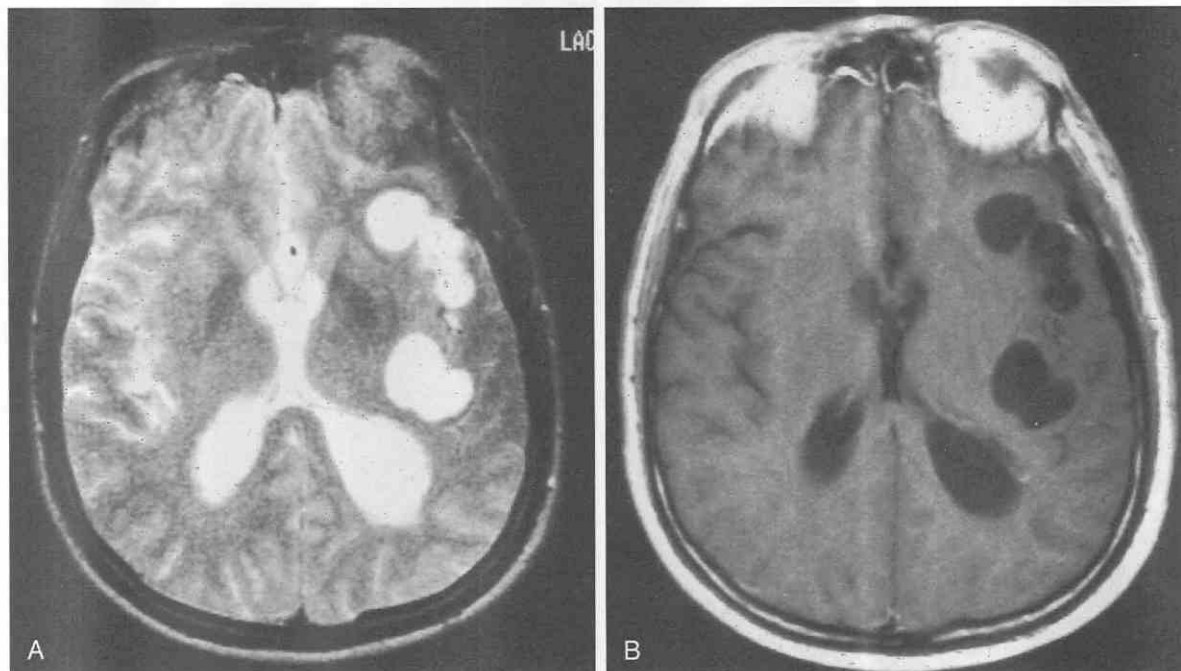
Cisternal cysts and intraventricular cyst. *A*, T2-weighted image shows multiple cisternal cysts in the region of the left sylvian fissure. *B*, Gadolinium-enhanced image shows multiple cisternal cysts in the region of the left sylvian fissure. No enhancement of these cysts is seen in this case. Incidentally, a cyst is seen in the atrium of the left lateral ventricle.
